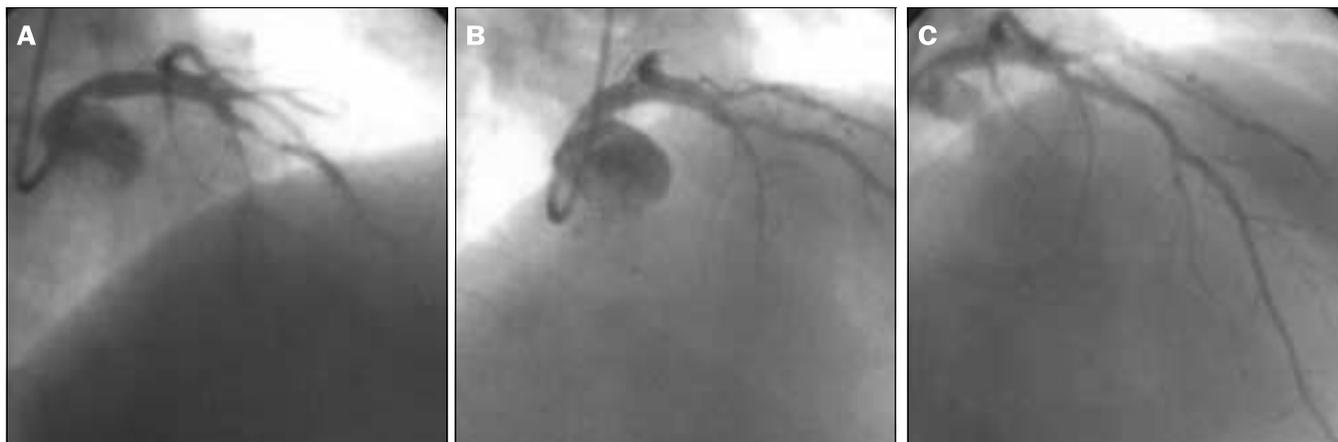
Angiogram of a 43 year old man who presented with chest pain of 2 hours duration and precordial lead ST elevations. [A] The diagnostic angiogram demonstrated a filling defect in the mid-portion of the left anterior descending coronary artery, consistent with a large thrombus and TIMI 1 flow. [B] Following therapeutic ultrasound thrombolysis, the filling defect has largely resolved, revealing a residual stenosis of approximately 40%. [C] Stent deployment eliminated the residual stenosis with TIMI 3 flow restored in the distal artery.
